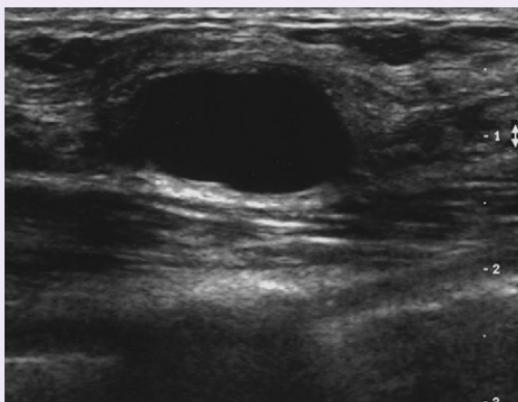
Ultrasound of a simple breast cyst. Note smooth borders, absence of internal echoes, and enhanced posterior echoes.
